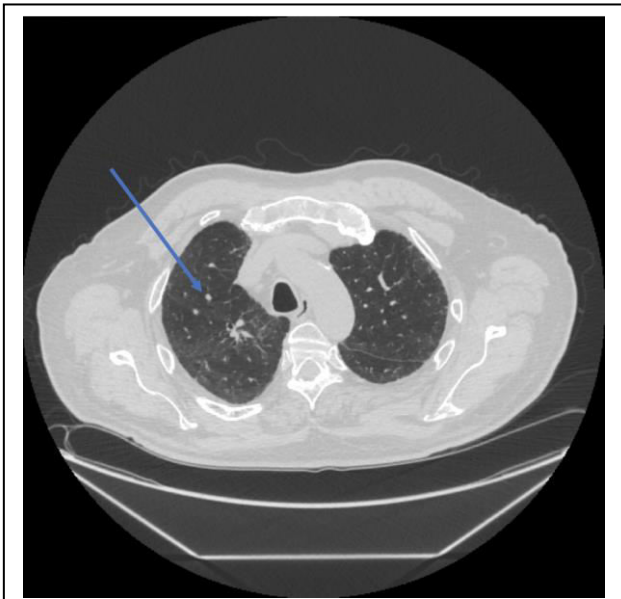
Initial CT image showing the largest nodule measuring 8mm.
